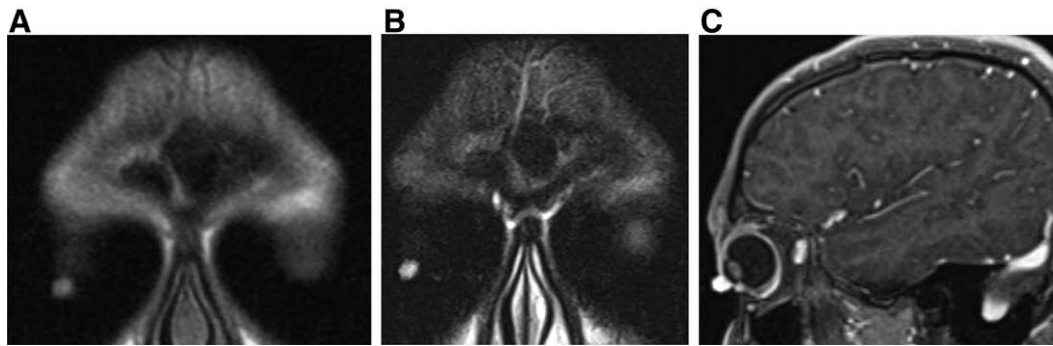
A, Coronal MRI T1-weighted image shows minimal intensity in upper eyelid region. B, Marked hyperintensity appears on T2-weighted imaging. C, Sagittal T1-weighted postcontrast imaging shows intense enhancement of the lesion.
